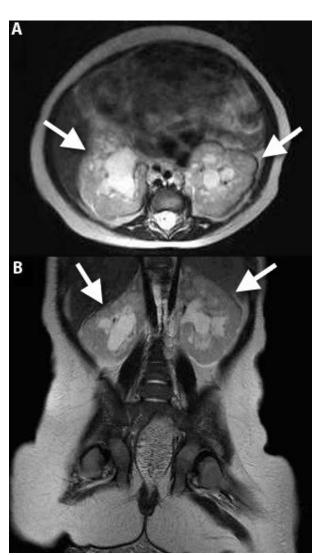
A 3-month-old girl with McKusick-Kaufman syndrome. Axial (A), Coronal (B) T2W MR images of kidneys shows bilateral hydronephrosis and dysplastic parenchyma (arrows).
